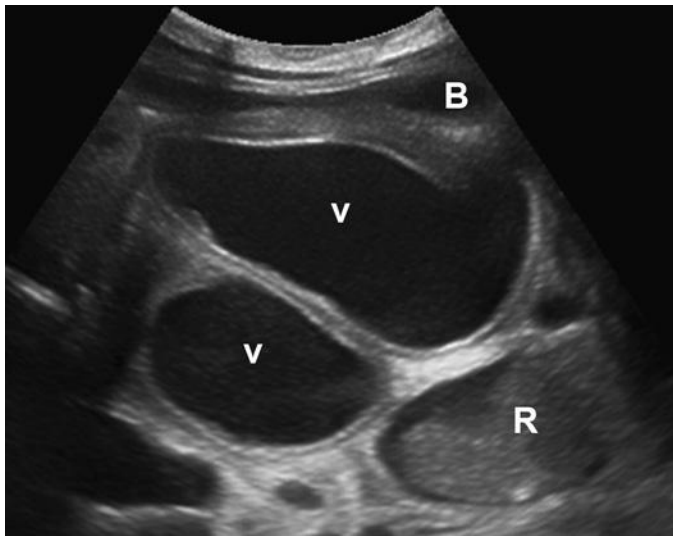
Cloacal malformation in newborn girl. Transverse ultrasound image of the pelvis shows duplicated vaginas (v) filled with fluid. The bladder (B) is anteriorly displaced and compressed. R, rectum. See Video 34-3.
